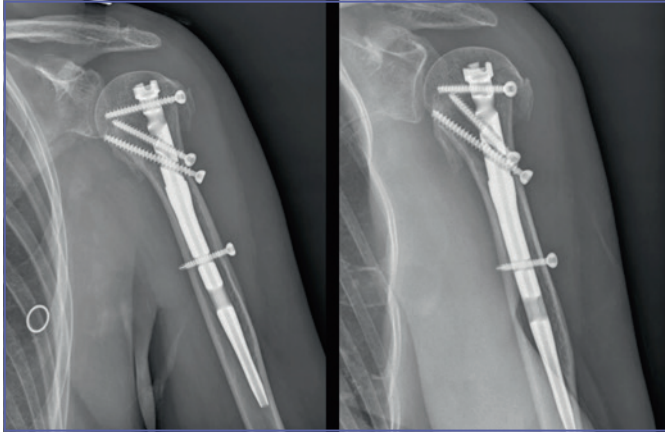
Radiographic result at the end of follow-up.
